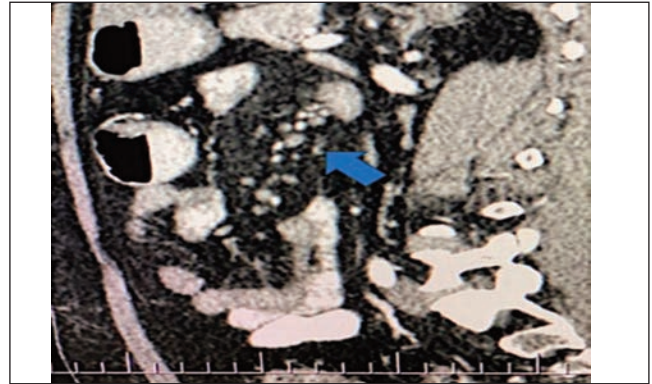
CT scan of the abdomen with contrast sagittal view of Case no. 3 showing an area of increased density of mesenteric fat at the root of mesentery which appeared misty with small mesenteric lymph nodes within it.
